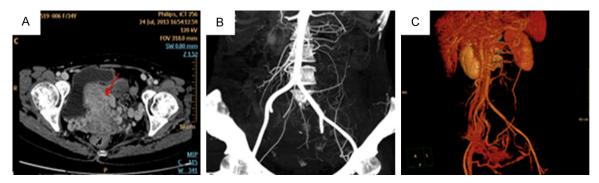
CTA scan. A: Demonstrated a large soft-tissue mass (red arrows) occupying the pelvic cavity. B and C: The left common iliac artery, internal iliac artery and external iliac artery were wrapped around the lesions, and many small vessels were sent into the mass. Local right common iliac artery was wrapped around the lesion. The lower part of the abdominal aorta was compressed and shifted to the right due to the mass.
